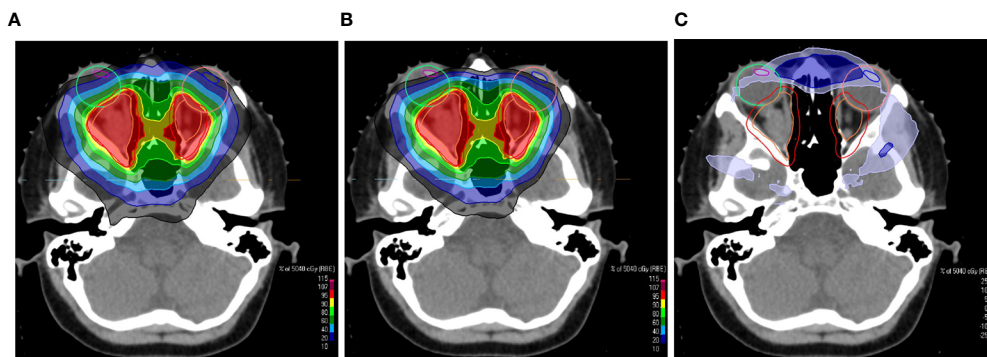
Transversal CT slices overlaid with a colorwash representation of the dose distribution of the uncollimated plan (A) and the plan with apertures (B) for the treatment of an opticus glioma. The screenshots of the treatment planning in RayStation show the dose sparing of the eye lenses, which are indicated by the blue and magenta contours. (C) shows the dose difference between the plans. The beams eye view of one of the treatment fields is shown in Figure 1.
